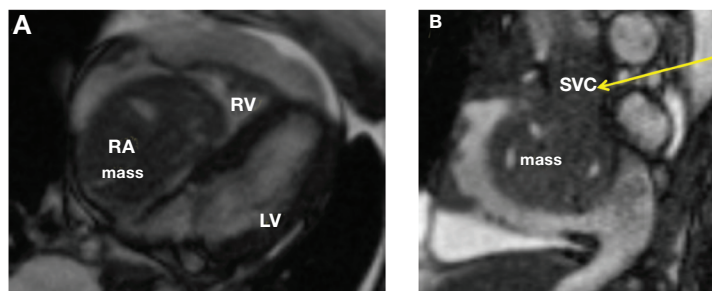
Cardiac magnetic resonance images of (A) four-chamber view and (B) sagittal view of the right atrium show the steady-state free precision images of the heart. There is a large mass in the right atrium (RA) and right ventricle (RV) encompassing the tricuspid valve and extending to the superior vena cava (arrow). (C) Four-chamber view is delayed hyperenhancement image showing significant contrast uptake by the mass.
